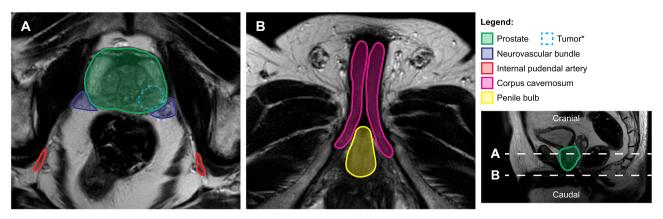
Axial representation of the prostate and surrounding erectile function–associated neurovascular structures on magnetic resonance imaging. *Hypothetical tumor location for which ipsilateral neurovascular bundle sparing is compromised, representing 68% of cases.
